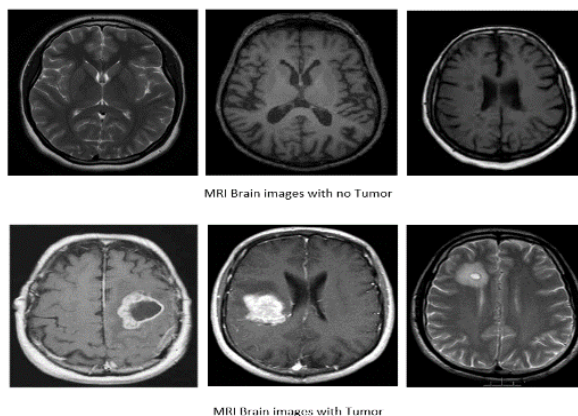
Magnetic Resonance Image of healthy brains and brains with tumor
